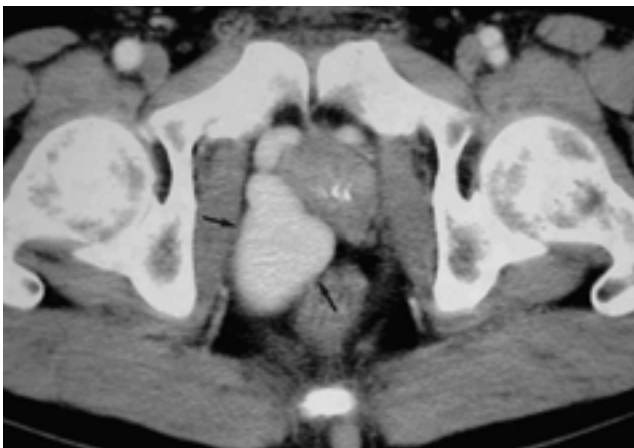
Pelvic CT scan shows dilated tortuous vessels occupying the pelvic space and a venous aneurysm(arrows).
